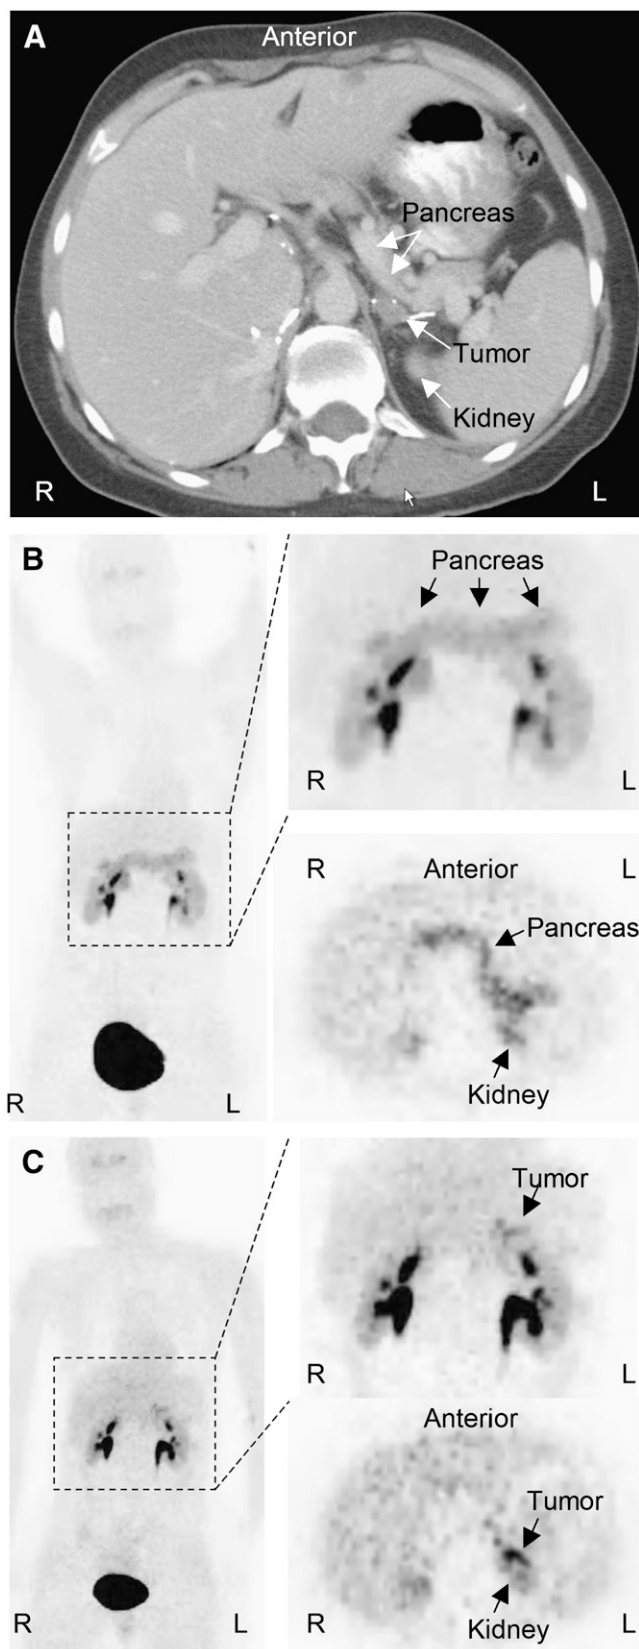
CT scan (A) and ^{18}F -DOPA PET scans without carbidopa (B) and after carbidopa (C) in patient 9. In PET scans, anterior reprojected images are at left, details of anterior reprojected images are at top right, and transverse sections
